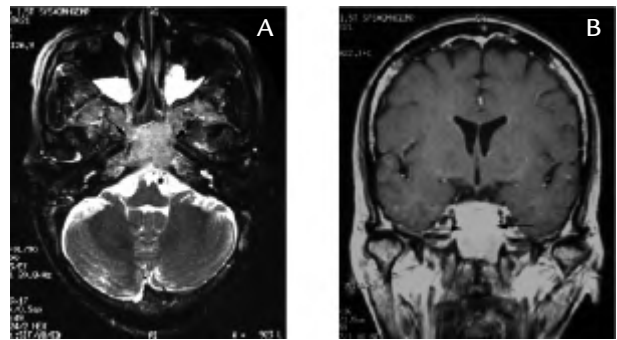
A. Post contrast T1-weighted axial scan through the brain showing enlargement of the clivus (arrows) with enhancing tissue. Note polyp in the left maxillary sinus and fluid in both maxillary sinuses B. Axial T2-weighted scan through the skull base showing abnormal signal in the basi-occiput (long arrow) and both hypoglossal canal (small arrows).
